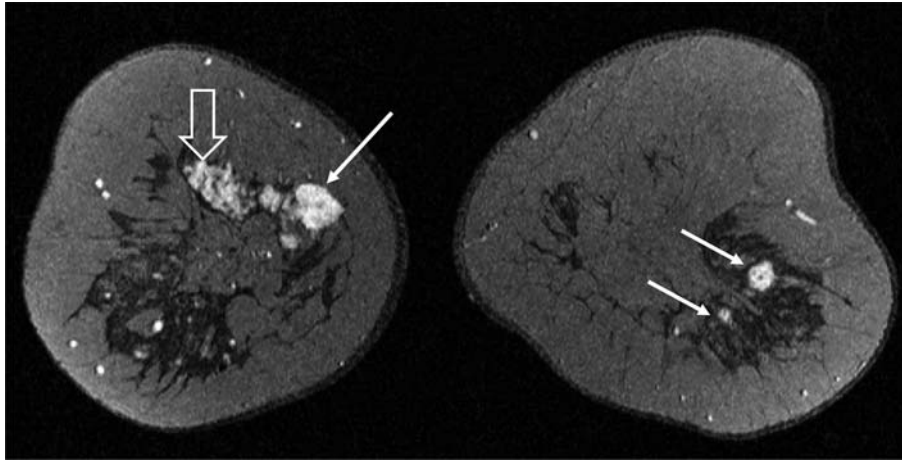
Dynamic contrast-enhanced T1-weighted images in a patient with multifocal and bilateral breast cancer. Note the solid, circumscribed nodules (*bold arrows*) that correspond to invasive foci. Additionally, there is an extensive in-situ component that is visible as a less intense, inhomogeneous area of contrast enhancement with a segmental configuration (*open arrow*).
